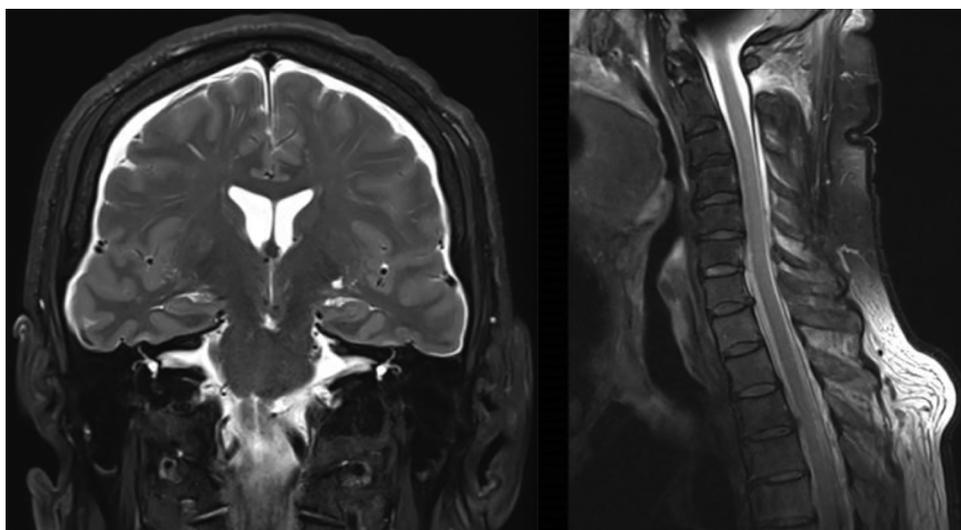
MRI T2 scans showing thin fronto-parietal, bilateral chronic subdural hematomas and detachment of the dura from the bony margins of the cervical spinal canal with hyperintensity signal in the interspinous soft tissues as of CSF leakage.
